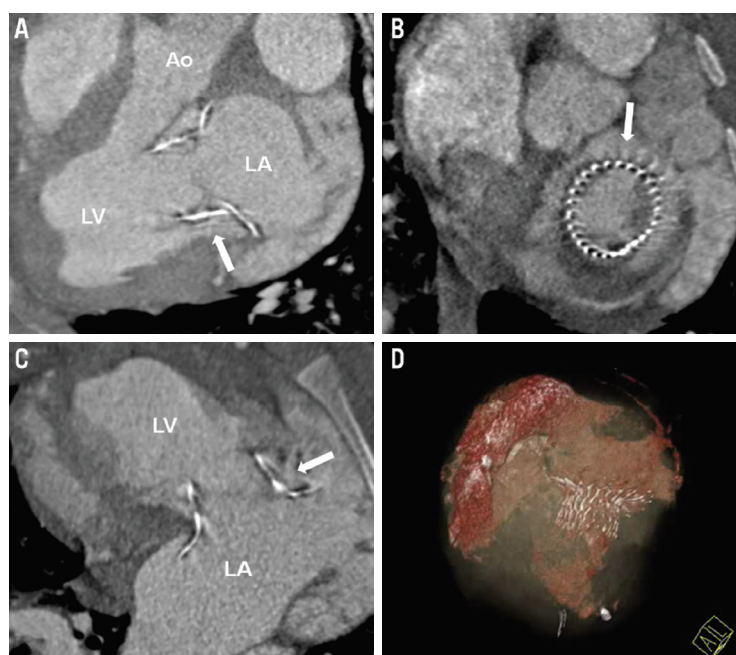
A-C: cardiac CT short- and long-axis standard views showing correct stent position and no left ventricular outflow tract obstruction of the 110° prototype 1 month after implantation; D: three-dimensional reconstruction showing the nitinol stent frame and left atrial and ventricular volumes. Reprinted from *EuroIntervention*, Pokorny et al.^[8], Transapical mitral valved stent implantation: computed tomographic evaluation of different prototype designs, 948-955. Copyright (2015), with permission from Europa Digital & Publishing. Ao: aorta; LA: left atrium; LV: left ventricle (white arrow indicates the nitinol stent frame)
